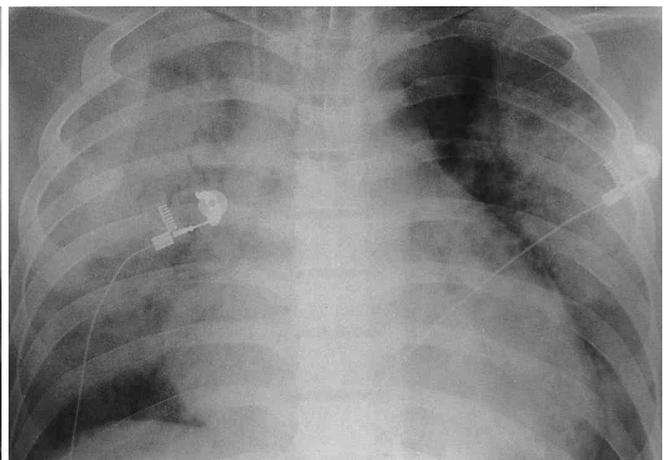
Hematogenous pneumonia in a 25-year-old man with major thermal burn. A. Chest radiograph taken 42 days after major thermal burn without inhalation injury shows multiple variable sized ill-defined nodules (arrowheads) in both lungs. Blood culture revealed *Staphylococcus aureus*.
